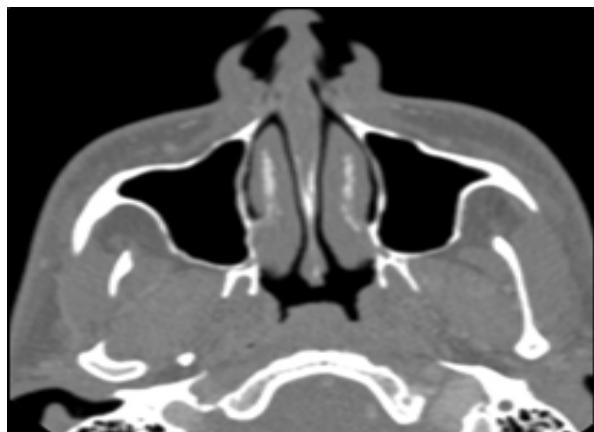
Computed tomography C.T image of a typical case, showing absence of any disease in the Maxillary antrum effectively differentiates this disease from any other Sinus disease. Only finding is the Inferior turbinate hypertrophy. This was found in all cases (100%)
